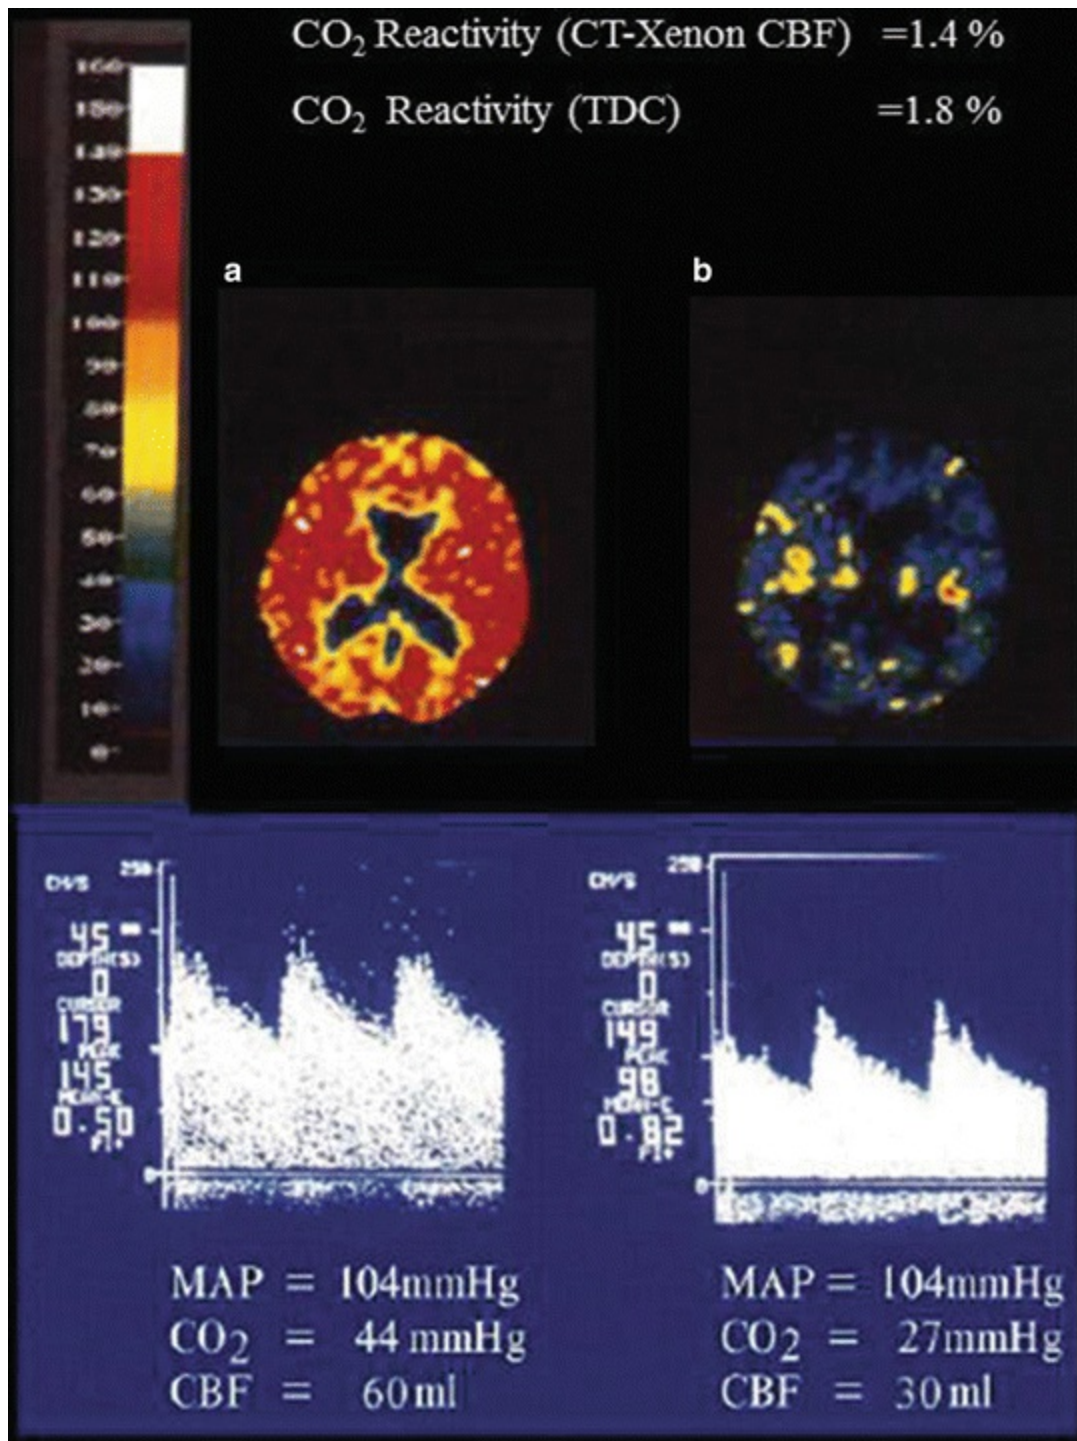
CO₂ reactivity in a patient with acute liver failure. (a) Cerebral blood flow (CBF) determined by CT-Xenon method and cerebral blood flow velocity (CBFV) determined by Transcranial Doppler ultrasonography (TCD) at PaCO₂ of 44 mmHg, mean artery pressure (MAP) of 104 mmHg. (b) Cerebral blood flow (CBF) determined by CT-Xenon method and cerebral blood flow velocity (CBFV) determined by Transcranial Doppler ultrasonography (TCD) at PaCO₂ of 27 mmHg, mean artery pressure (MAP) of 104 mmHg
